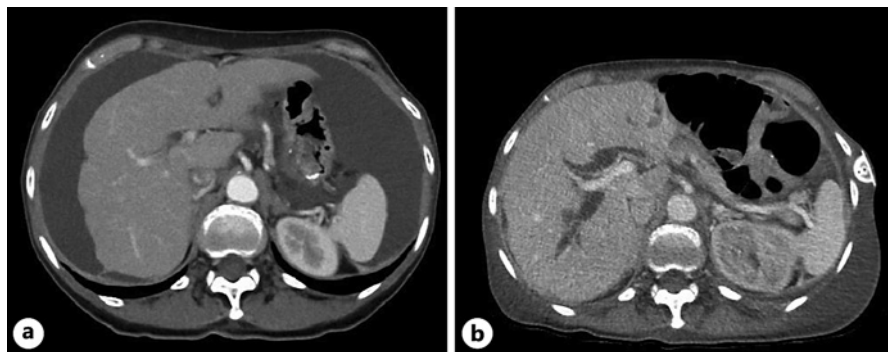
Abdominal CT. a Before extracorporeal PVS. b 15 days after insertion of the Denver shunt.
